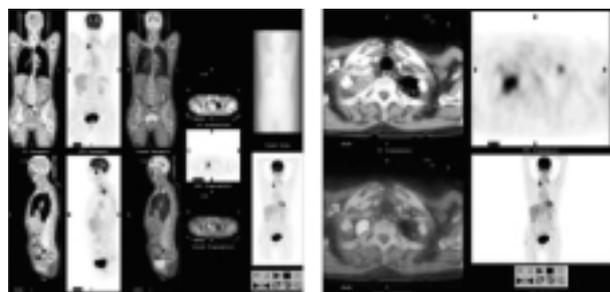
A 61-year-old woman with a Pancoast tumor of the right lung. (A) Full computer screen with CT, PET, PET/CT scans and maximal intensity projection (MIP) showing the extent of disease. No evidence for further malignant lesions. (B) Transaxial contrast enhanced CT, PET, and PET/CT scans showing that the tumor has contact with the right A. subclavia which represents tumor infiltration of the thoracic wall.
